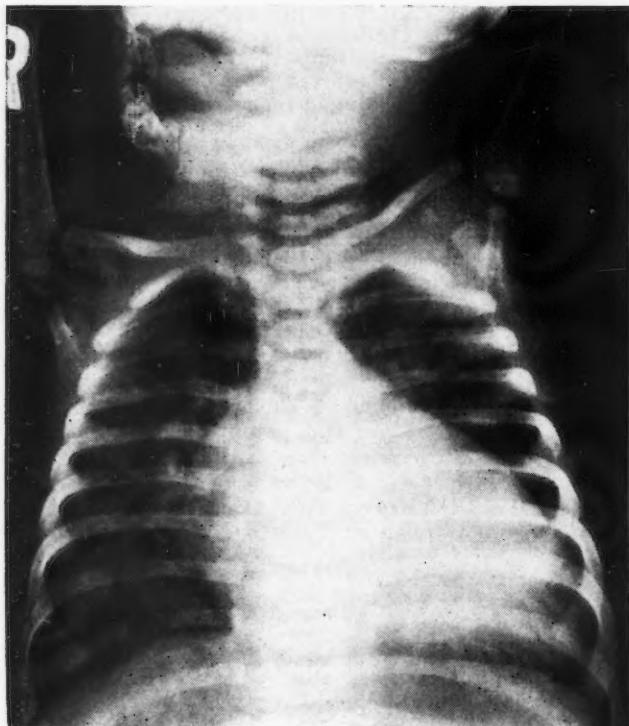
X-ray appearance of the heart in typical case of transposition of the great vessels.
